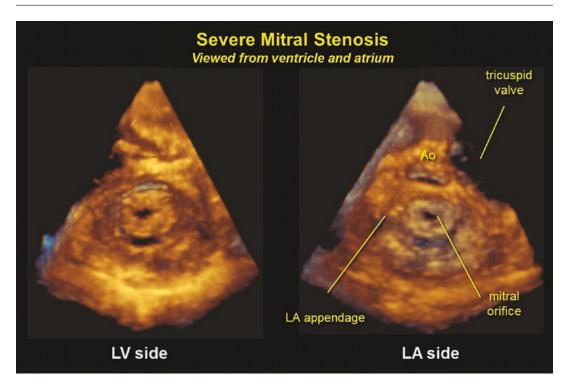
Three-dimensional echocardiographic still frames showing a severely stenotic mitral valve orifice from the ventricular (left) and atrial (right) perspectives.
